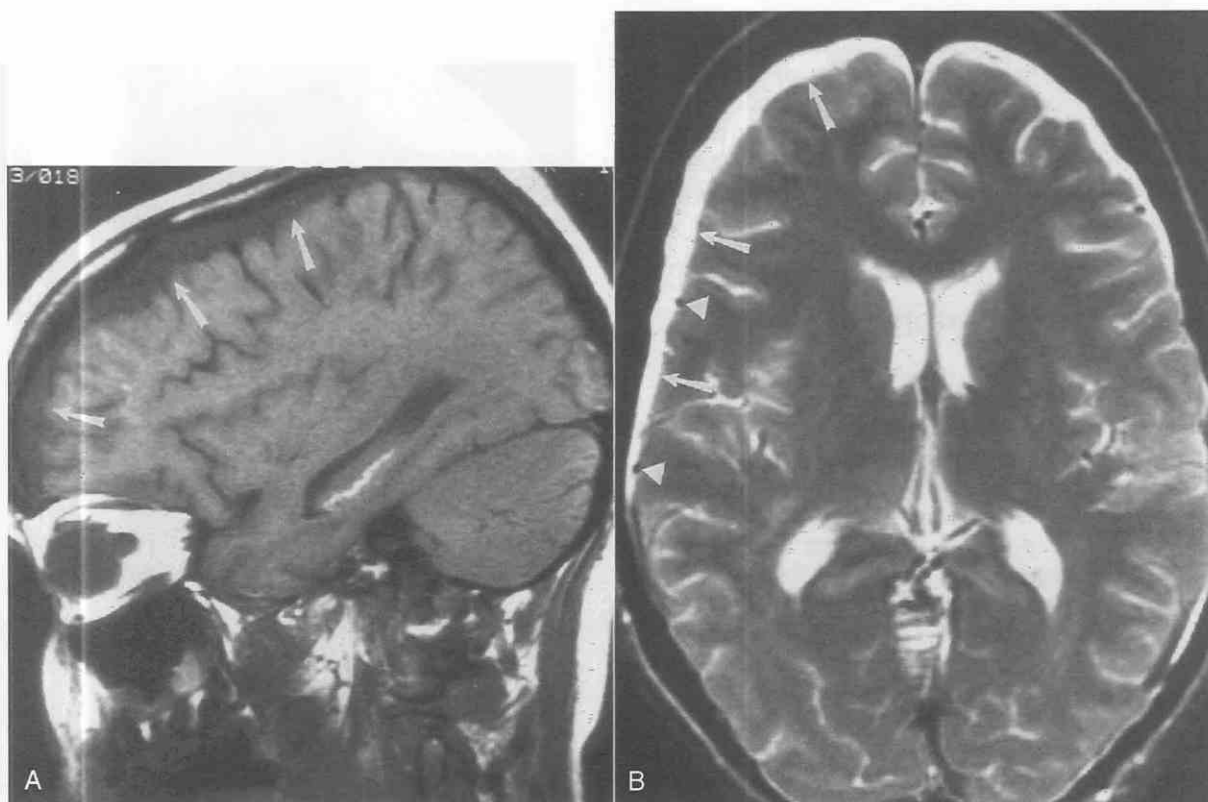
A and B, Right frontal convexity chronic subdural hematoma is slightly hyperintense on sagittal T1-weighted (500/15) and isointense on axial T2-weighted (2500/80) MR images relative to cerebrospinal fluid (arrows). Note displacement of the subdural veins away from inner table of the calvarium (arrowheads). A small left frontal convexity subdural hemorrhage is present.
